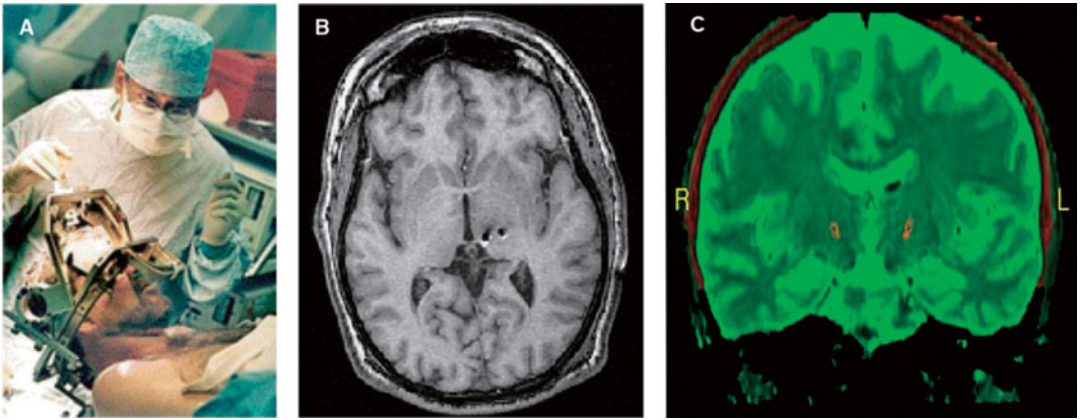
(A) Intraoperative awake deep brain stimulation. (B) Axial MRI of deep brain stimulators for pain in situ. (C) Fused coronal CT and MRI showing subthalamic nuclei targeted in deep brain stimulation for Parkinson's disease. (After Pereira *et al.*, 2007.)
